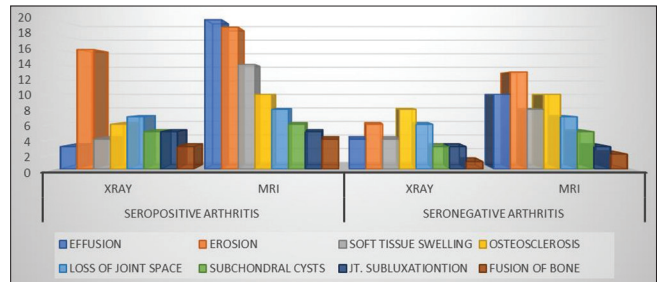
Comparison between X-ray and magnetic resource imaging in detecting seropositive and negative findings
